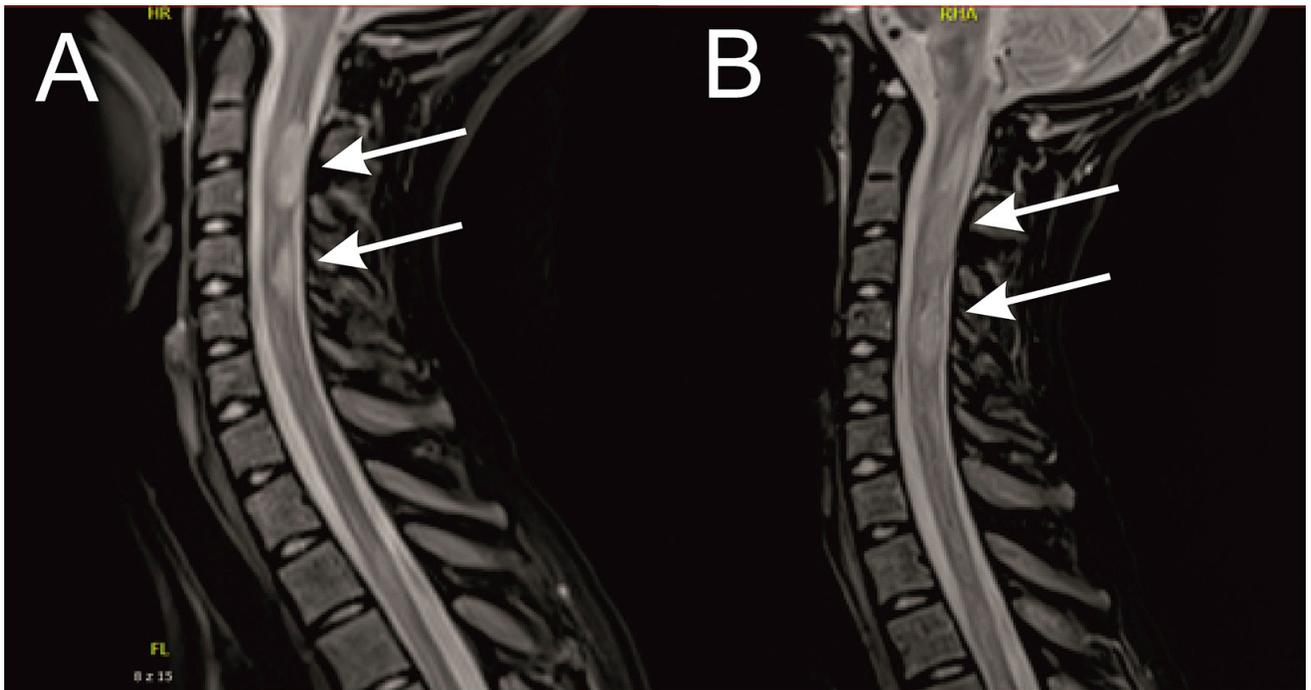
Cervical spine MRI
